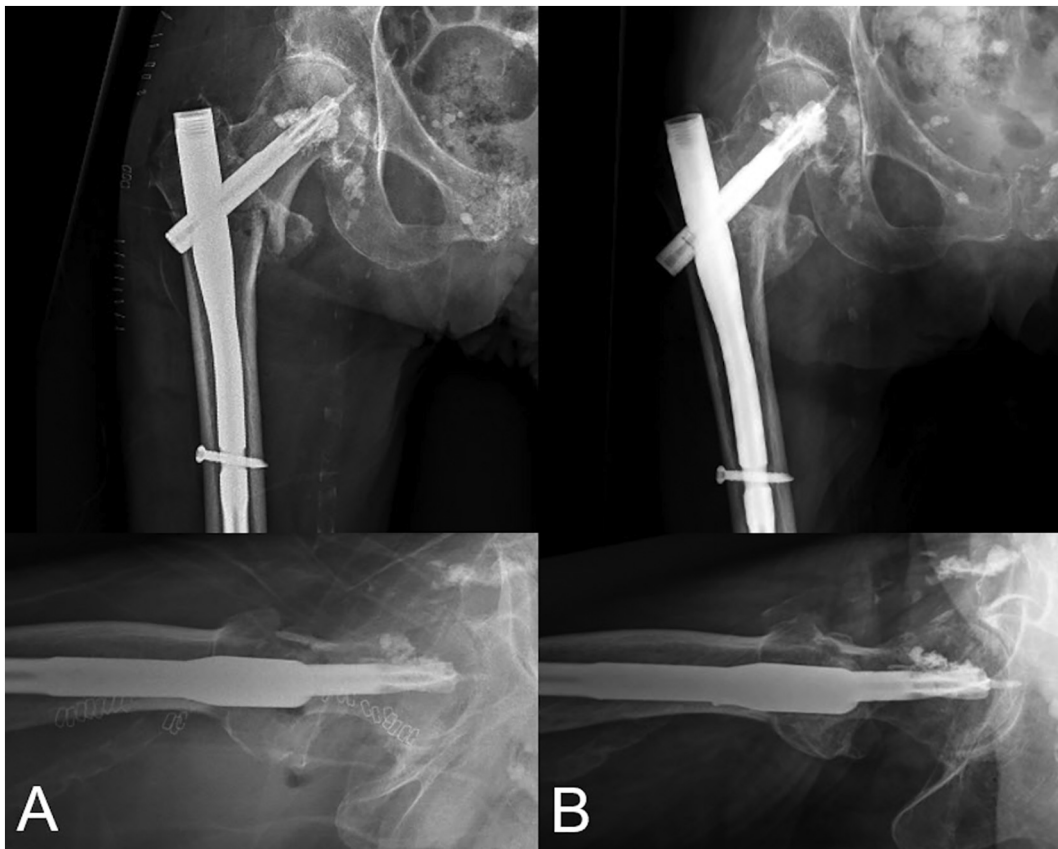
Radiographs (A) Directly postoperative after the aforementioned revision. (B) At one-year follow-up. Fracture consolidation is visible; neither secondary dislocation nor implant migration is visible.
